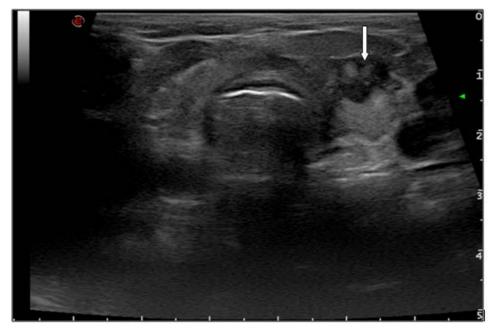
Thyroid ultrasonography
